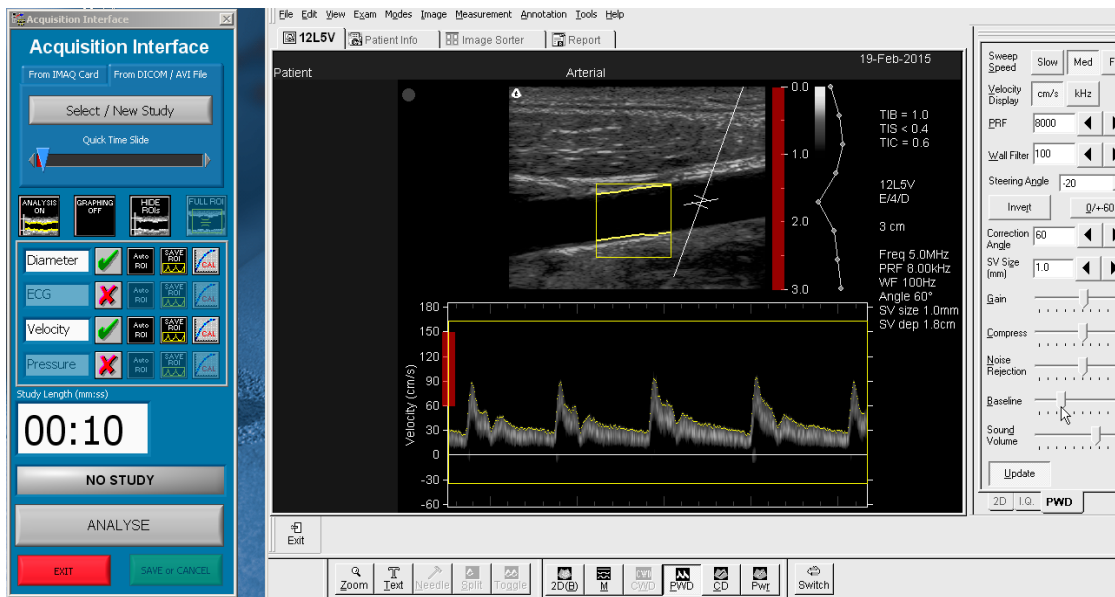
Analysis of flow-mediated dilation (FMD) data using custom designed automatic edge-detection and wall-tracking software. The yellow boxes represent regions of interest (ROI) that have been selected to identify the arterial wall-lumen interface and the Doppler waveform.
